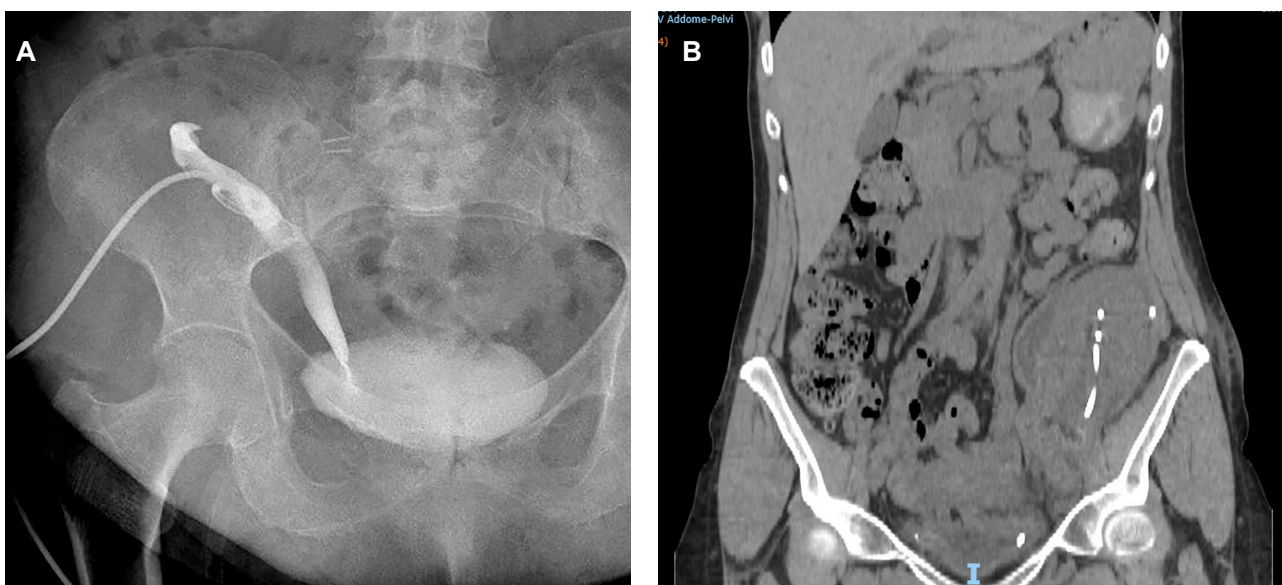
Images of urinary complications. (A) Urinary stricture: plain X-ray demonstrating the ureteral stricture of transplanted kidney by percutaneous pyelography in a kidney transplant recipient with urinary stricture. (B) Urinary leak: Computer Tomography scan demonstrating the peri-renal collection in a kidney transplant recipients with urinary fistula.
